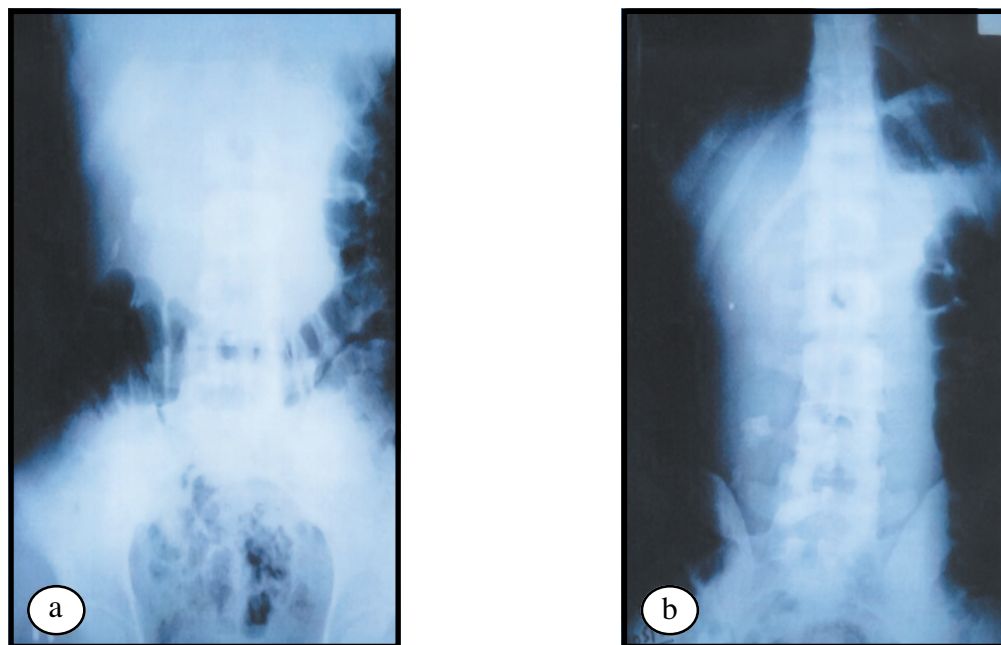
Supine and erect plain x-ray of a 25-year old male, (a) showing stones at the renal pelvis. (b) Lower calyx of a right nephroptosed kidney.
